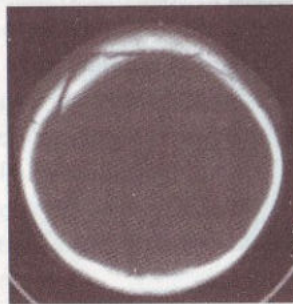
CT scan showing linear fracture right frontal bone
